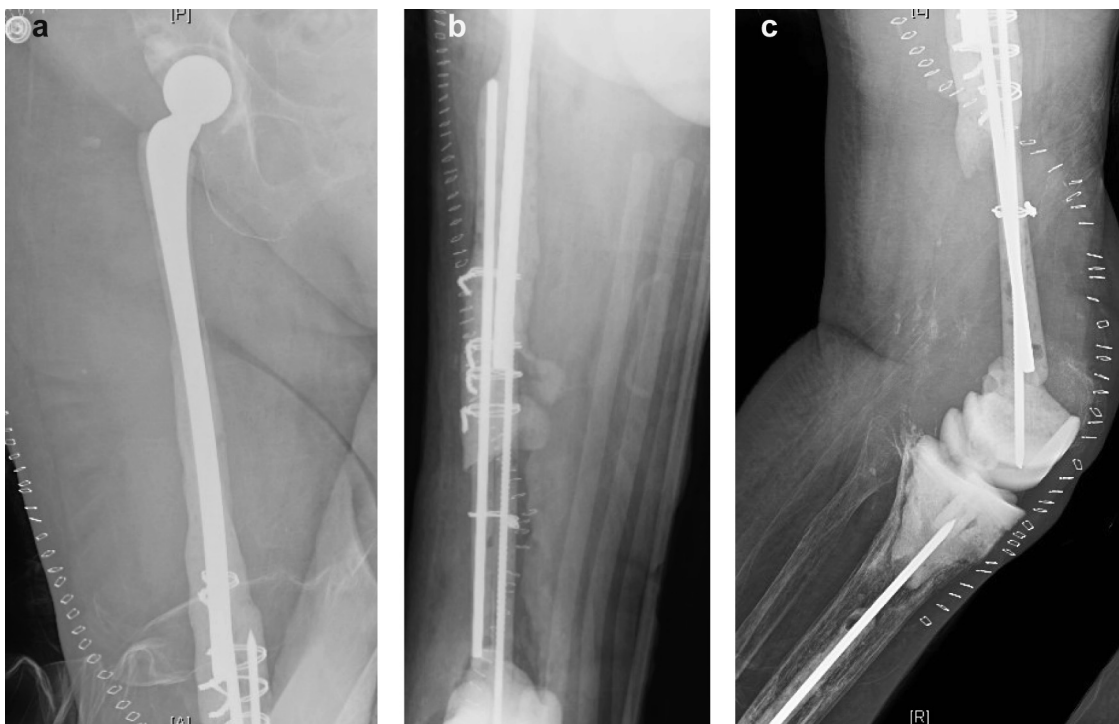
Postoperative anteroposterior (AP) (a and b) and lateral (c) radiographs of a dual-articulating total femur spacer implanted in patient 1. AP, anteroposterior.
